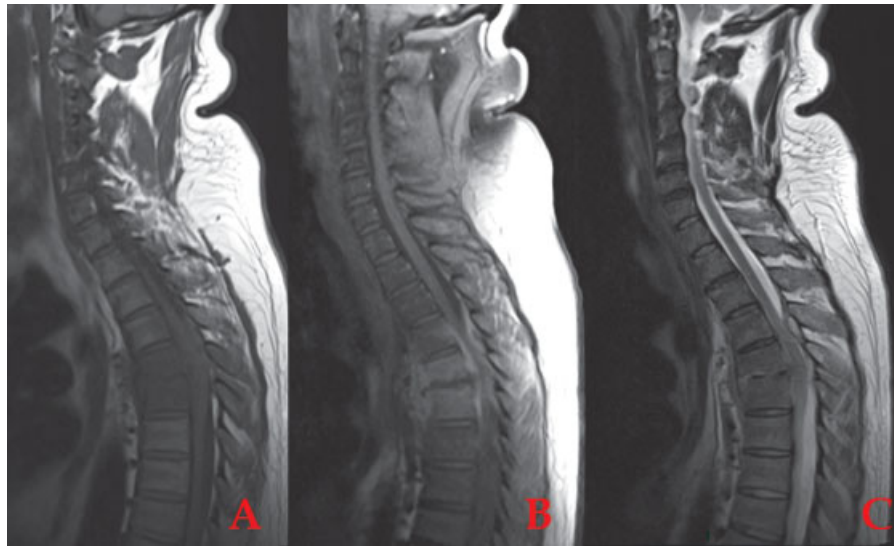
Magnetic resonance imaging scan on admission. Lesion with a low T1-weighted (A) and high T2-weighted (C) signal in the T5–T6 vertebral body with high postcontrast enhancement (B), involving the T5–T6 disk and the left anterior prevertebral soft tissues; an epidural abscess is also evident, resulting in slight spinal cord compression.
